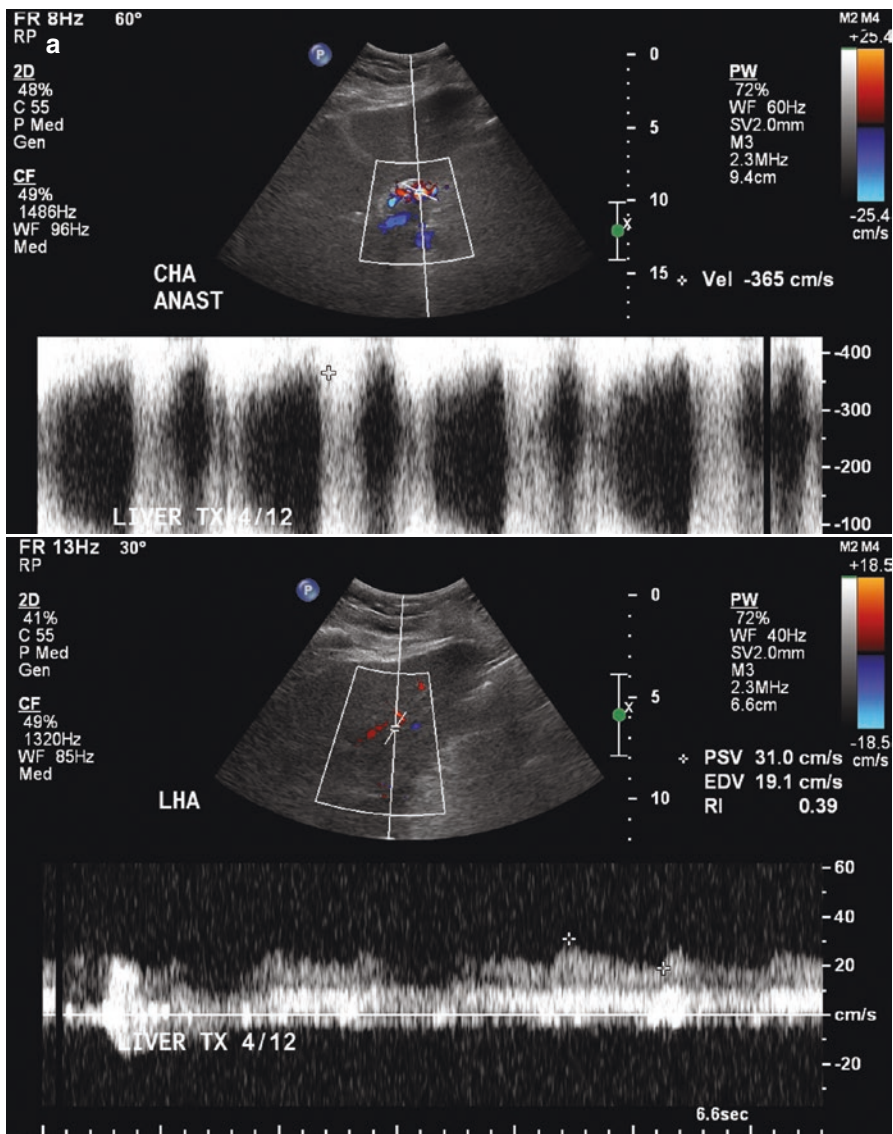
Hepatic arterial stenosis: (a) Color doppler images of the transplant arterial vasculature demonstrating findings consistent with high-grade anastomotic stenosis. (b) Reconstructed CTA confirming the sonographic findings. (c) Pretreatment DSA of the high-grade stenosis. (d) Balloon angioplasty of the stenotic segment. (e) Post-angioplasty DSA demonstrating improved stenosis
